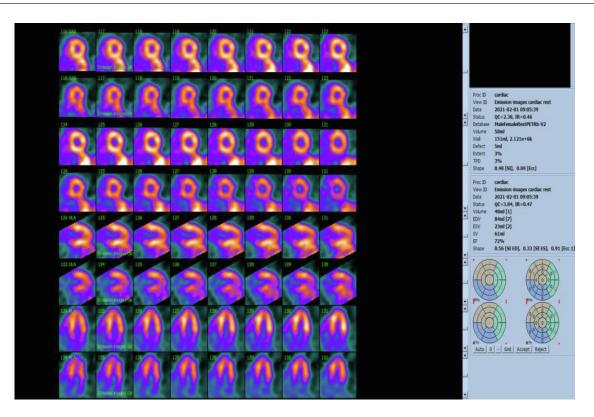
18 F - FDG uptake showing diffuse myocardial uptake suggestive of myocarditis.
